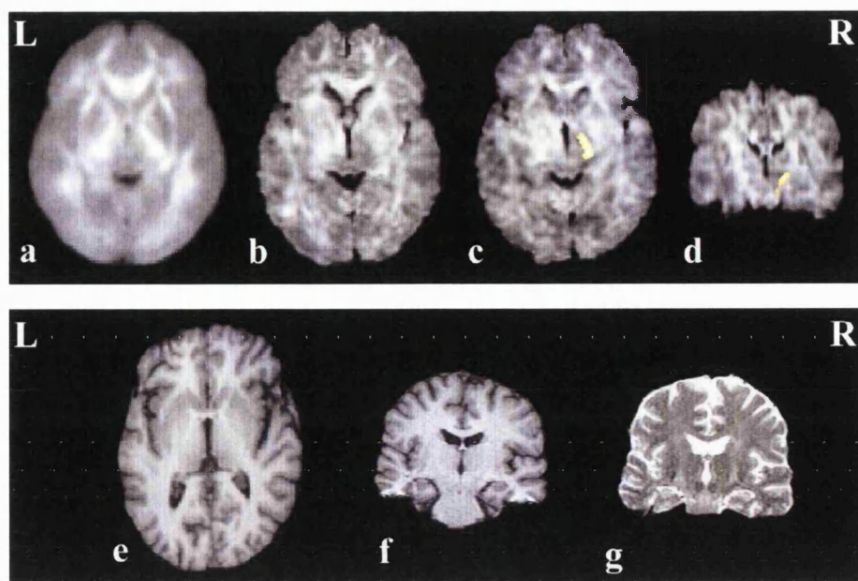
Patient 2. Normalised axial fractional anisotropy maps at the same slice position for the averaged 30 control subjects (a) and the patient (b) and (c). Normalised coronal anisotropy map (d). The difference in signal to noise between the maps is due to averaging of the 30 control subjects. The region of significantly decreased fractional anisotropy is superimposed on maps (c) and (d). The equivalent slices of the patient's T1-weighted axial (e) and coronal (f) and T2-weighted coronal (g) images show no abnormality. The region in (c) was used for quantitative region-of-interest analyses of fractional anisotropy values.
